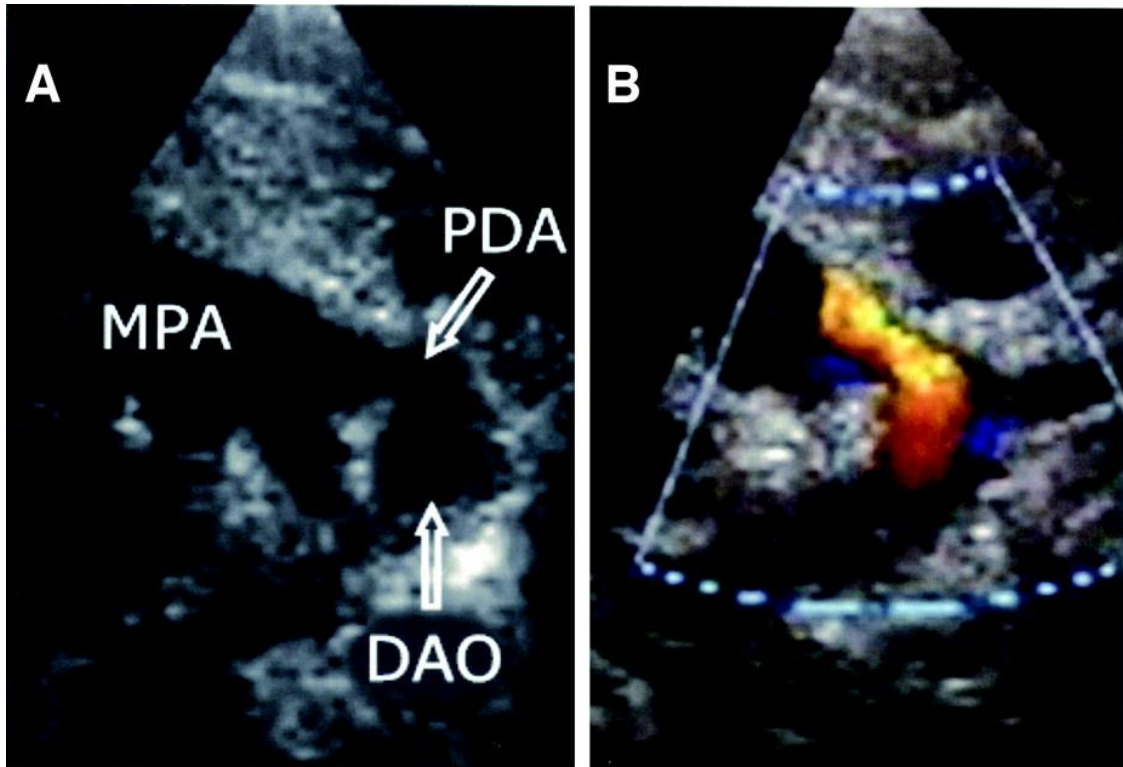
Echocardiograms of persistent ductus arteriosus (PDA). (A) 2D high parasternal short-axis view of PDA. DAO is the descending aorta and MPA is the main pulmonary artery. (B) Color Doppler image in the same view as A¹².
